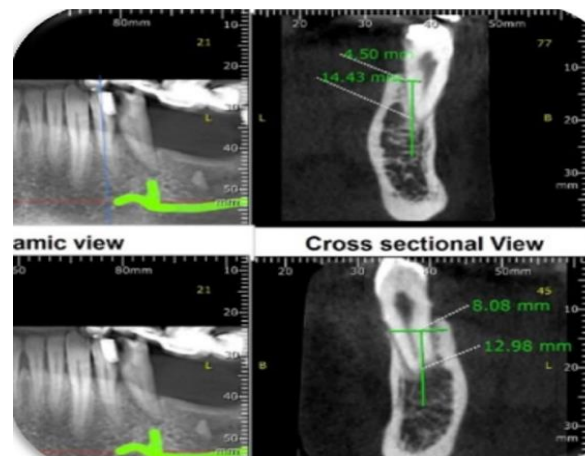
Cone Beam Computed Tomography And distance to inferior alveolar nerve with drill direction
